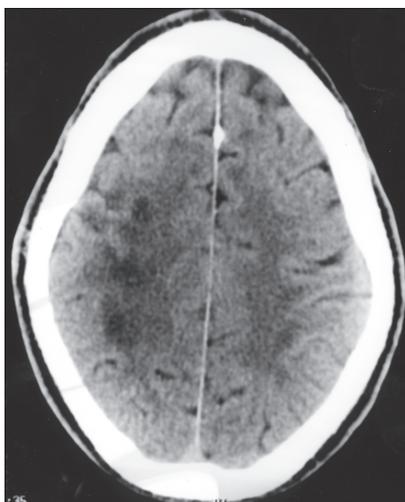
Axial non-contrast brain CT scan showing multiple and bilateral lacunar infarcts in the subcortical white matter of both parietal lobes, right more than left.
